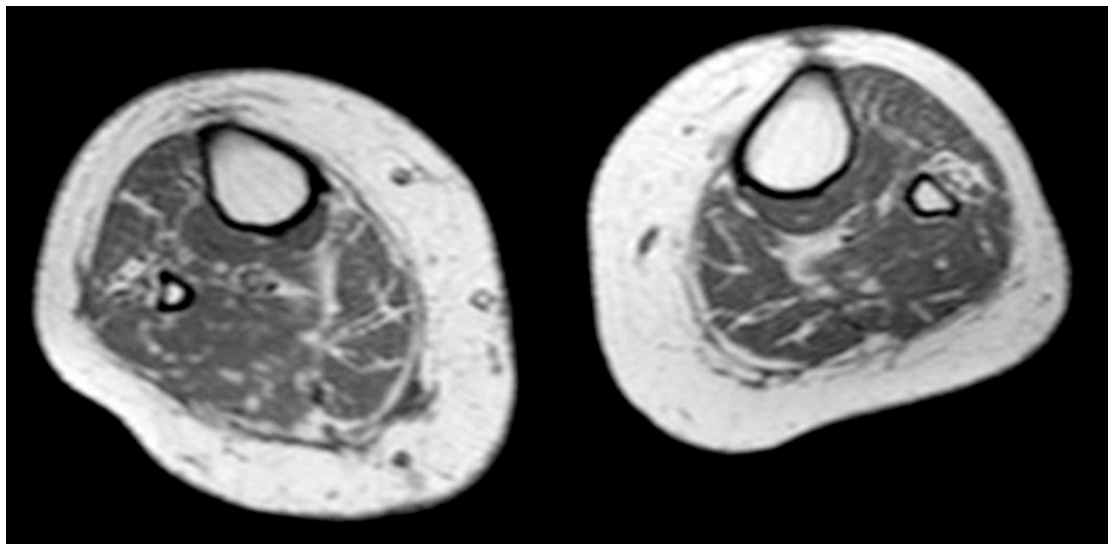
MRI scan of participant 4 gastrocnemius pre-treatment
